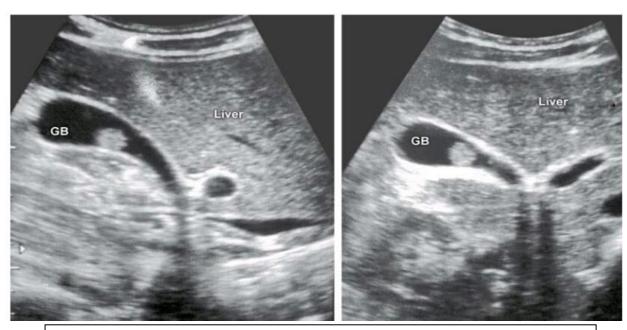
ultrasound abdomen showing multiple stones in lumen of gall bladder
